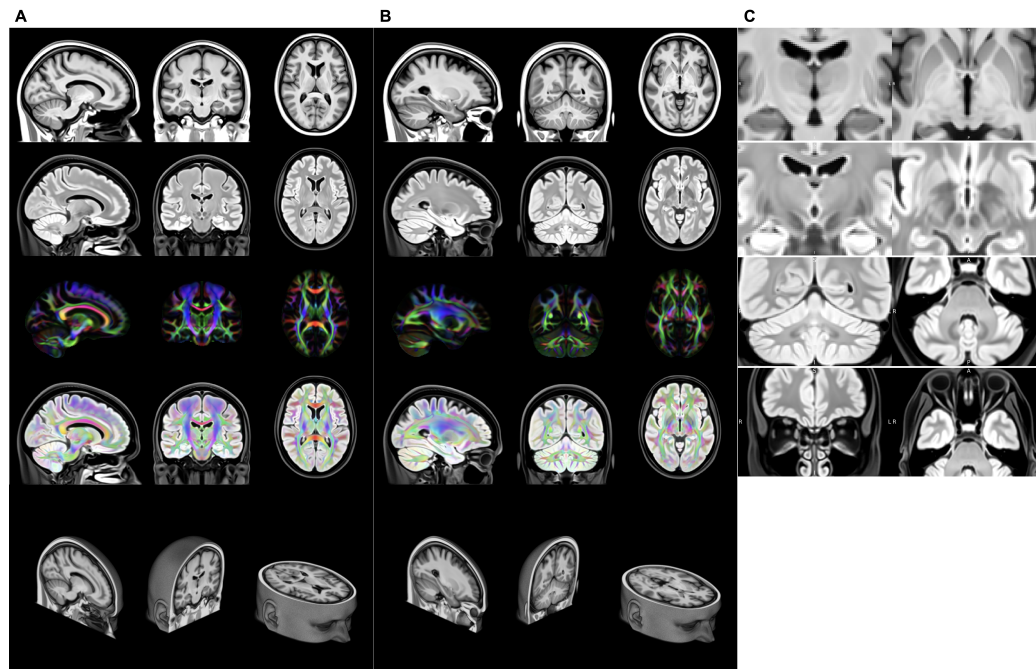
Two different sets of slices (A) and (B) through the modalities of the final OMM-1 template: T1, T2-FLAIR, DTI (visualised using a principal diffusion direction colour-coded FA map where AP=Green, LR=Red, IS=Blue), DTI overlaid on T2-FLAIR, and the corresponding slice in the 3D T1 volume. Scalar T1 and T2-FLAIR volumes exhibit very good contrast. The DTI volume shows excellent sharpness and orientational consistency. Alignment between scalar and tensor modalities is exceptional as can be seen in the overlay of DTI and T2-FLAIR. Facial features such as the ears, nose and eyes show a high level of detail. Coronal and axial slices show the right hemisphere on the left and vice versa. Zoomed-in views of four ROIs in (C) highlight the excellent alignment across all 240 participants. The medial medullary lamina - separating internal from external globus pallidus - is clearly visible in the axial view of the T1 volume. On the T2-FLAIR volume a clear separation of the subthalamic nucleus and substantia nigra can be seen in the coronal view, as well as the dentate nucleus in the cerebellum and the olfactory bulbs are clearly visible.
